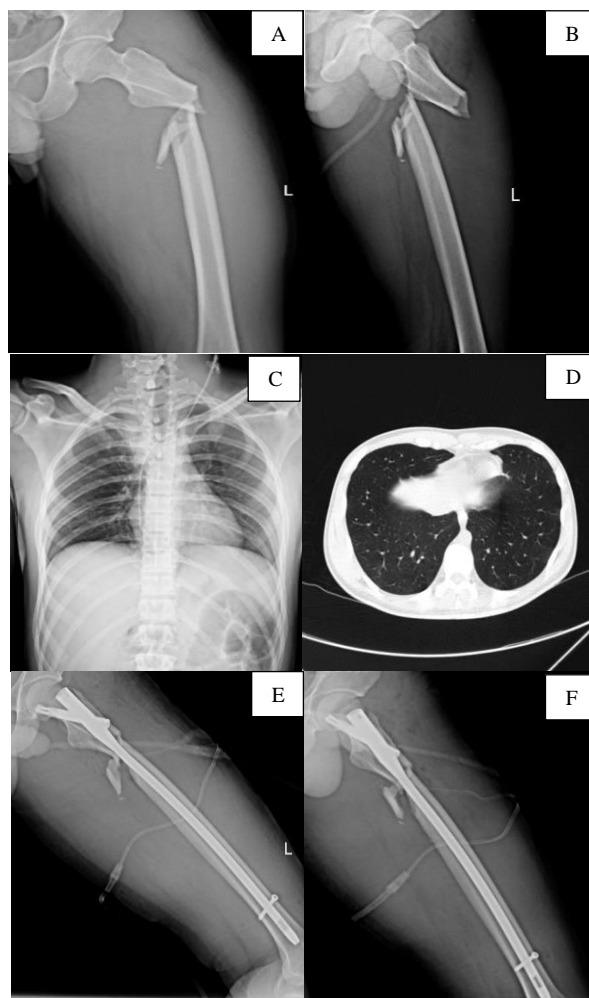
Case 4: A and B) preoperative radiographs of the patient, C) chest X-ray, D) chest computed tomography (CT) scan, E and F) postoperative radiographs
